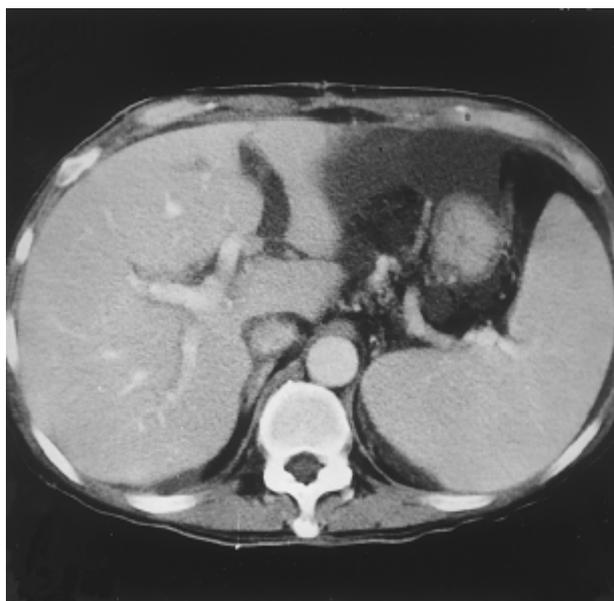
Abdominal computed tomography shows mild dilatation of intrahepatic bile duct (Case 2).
